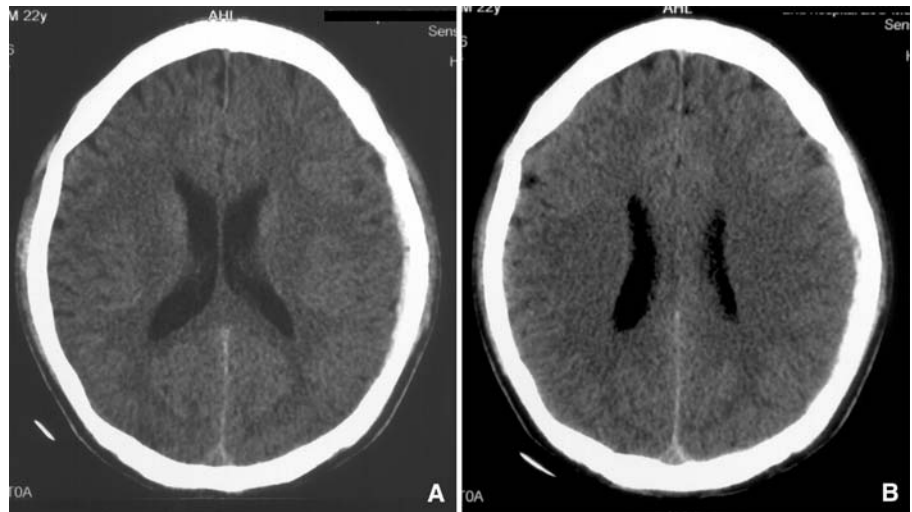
a, b A second CT scan obtained 4 h after admission disclosed a manifest decrease in the size of hematoma, the mass effect and midline shift could not be noted at that time
